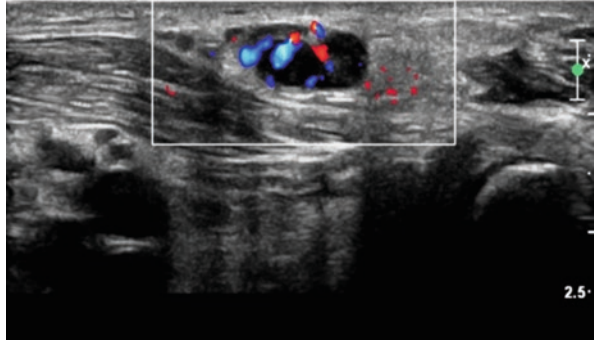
High-resolution ultrasonography showing enlarged size and hyperechoic structures within indicative of a thickened right ulnar nerve
